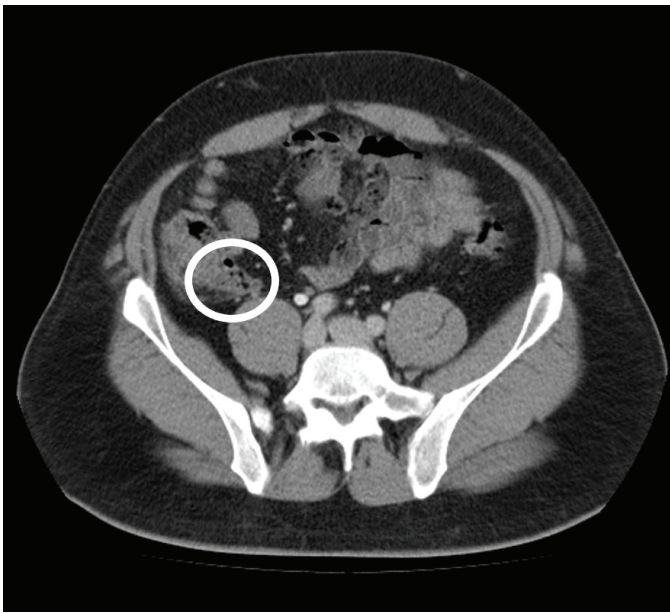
CT image of the cecum, diverticulitis formation showed in the white circled area
